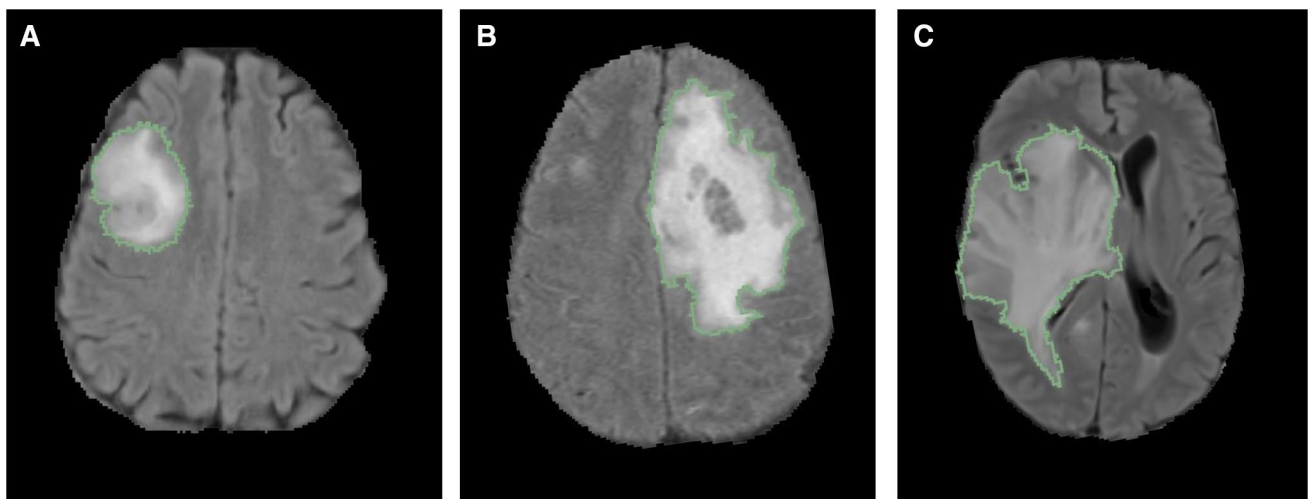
FLAIR tumor segmentation of a a grade II, b grade III, c grade IV. Segmentations shown are overlaid on axial, non-contrasted FLAIR image
